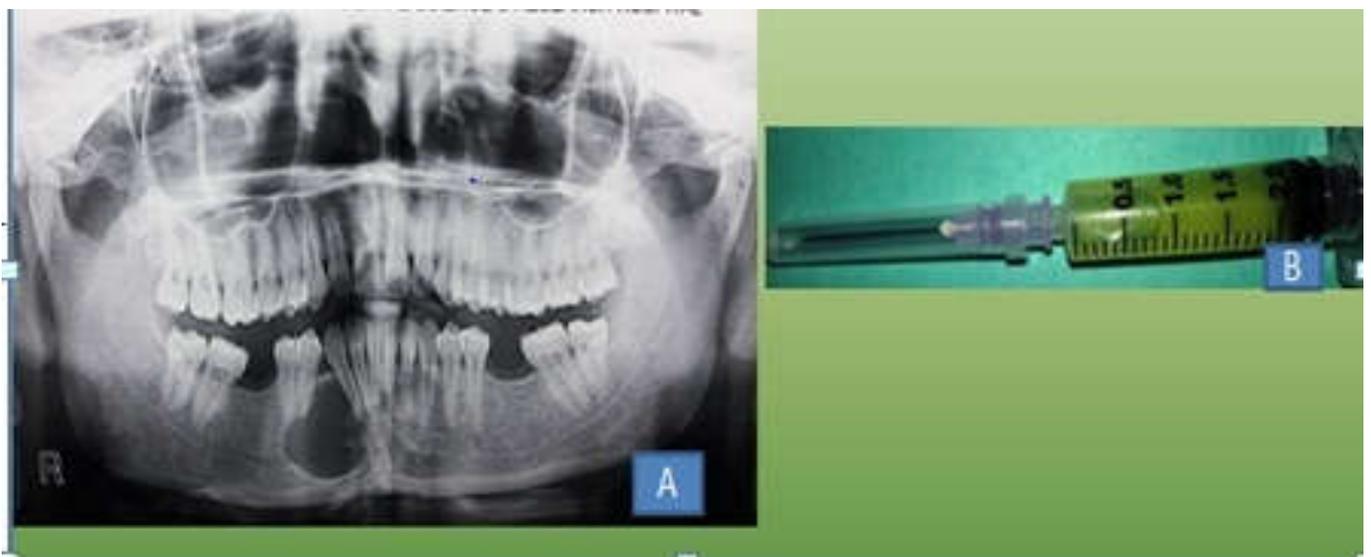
(A) Orthopantomograph (OPG) of the jaws revealed a large, unilocular radiolucency involving the periradicular area of lower right lateral incisor extending up to the distal aspect of the root apex of right second premolar associated with displacement of regional teeth. 2(B) Clinical photograph showing aspirated straw coloured fluid
